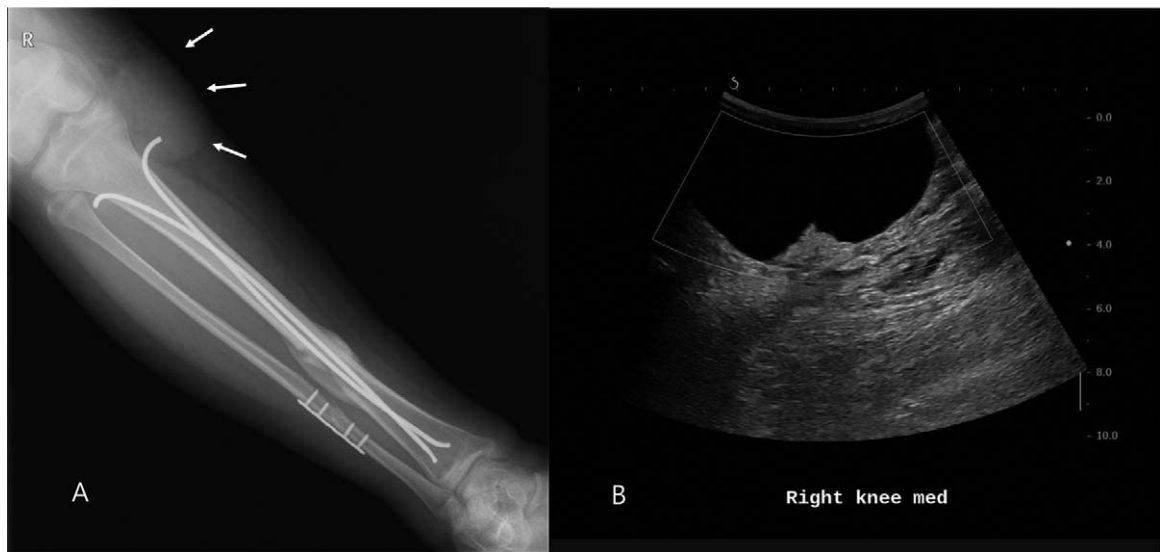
(A) A plain radiograph revealing a subcutaneous round radio-opacity in the proximal calf; and, (B) homogeneous, hypoechoic fluid collection evident on ultrasonography.
